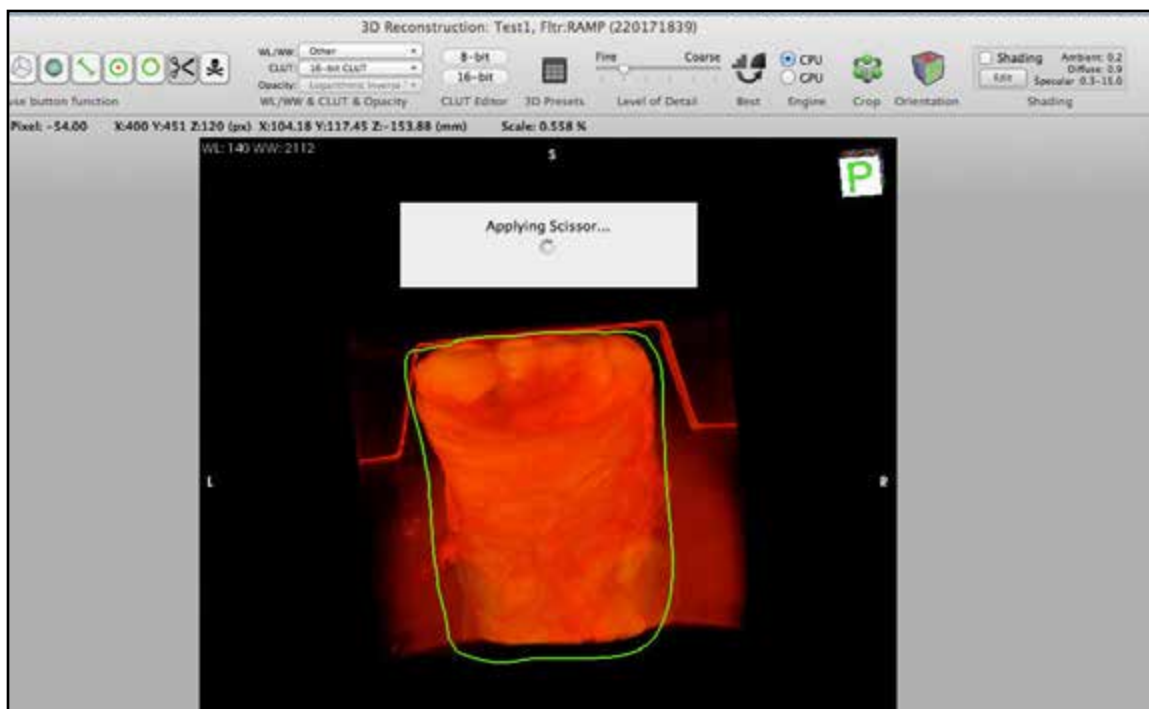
Trimming CT volume render with the scissors tool in OsiriX.
